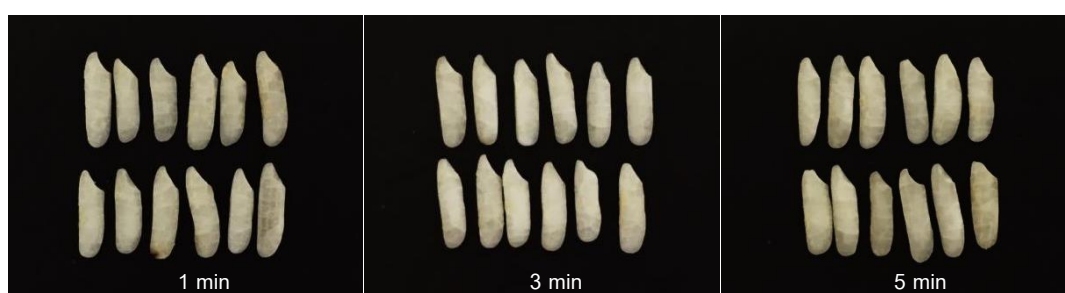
Appearance of rice grain from ultrasonic treatment
